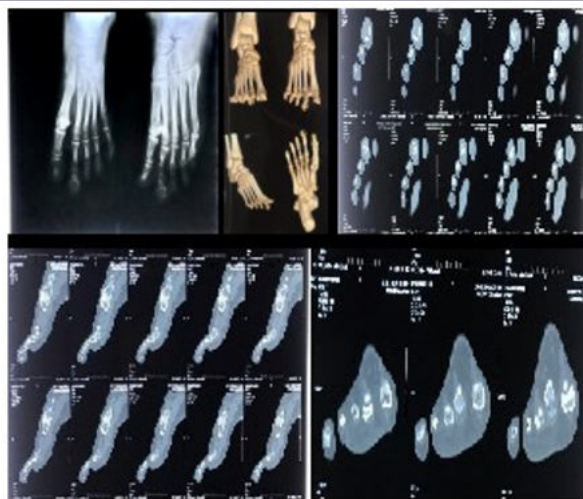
Pre-op X-ray And Ct Scan
